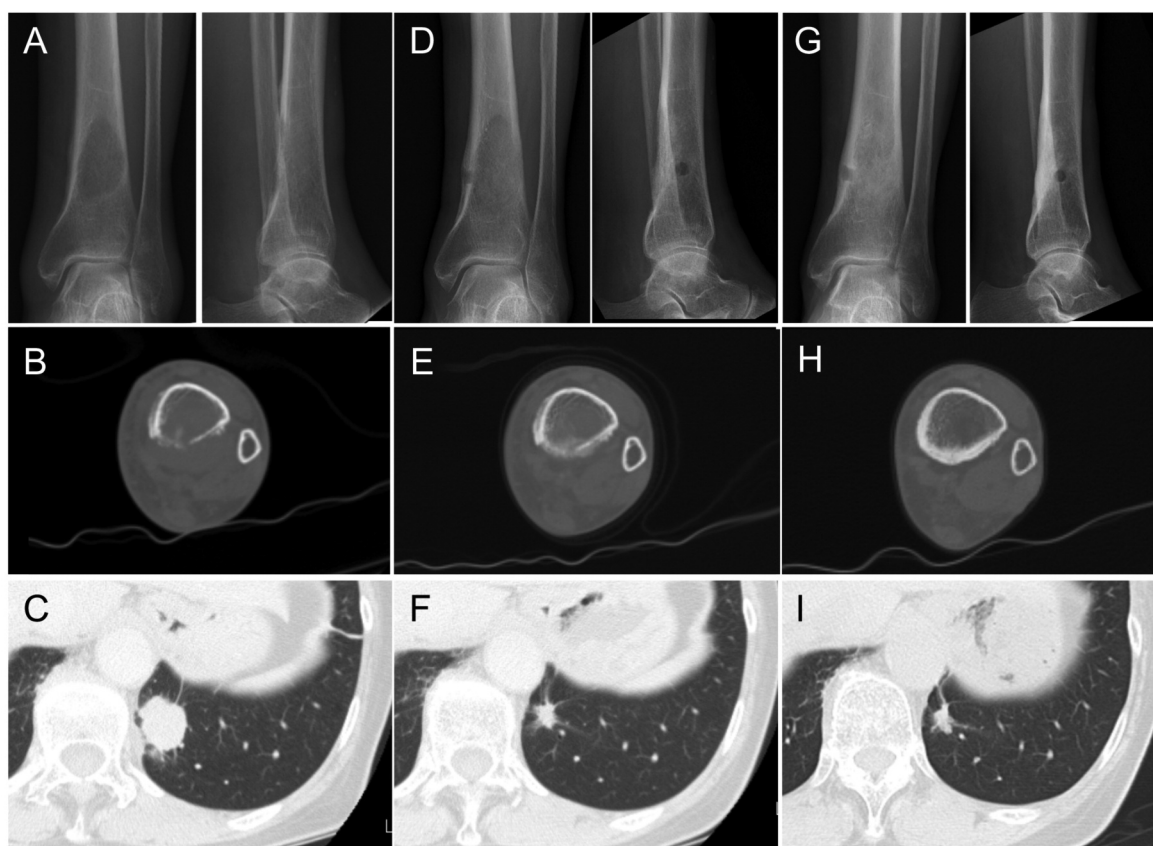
Case 1: A 74-year-old woman who had no past medical history presented with left ankle pain. A pre-therapy X-ray showed a radiolucent lesion on the left distal tibia (A). computed tomography (CT) showed a thinning and partial defect of the cortical bone (B). CT of the chest revealed a lung tumor at the same time (C). Three months after initiating pembrolizumab, X-ray and CT showed a remarkable osteosclerotic change in the bone metastatic lesion (D, E). CT showed a reduction in the size of the lung tumor (F). After 19 months of pembrolizumab, X-ray and CT showed almost complete repair of the metastatic bony lesion (G, H), and CT showed shrinkage of the lung tumor (I).
